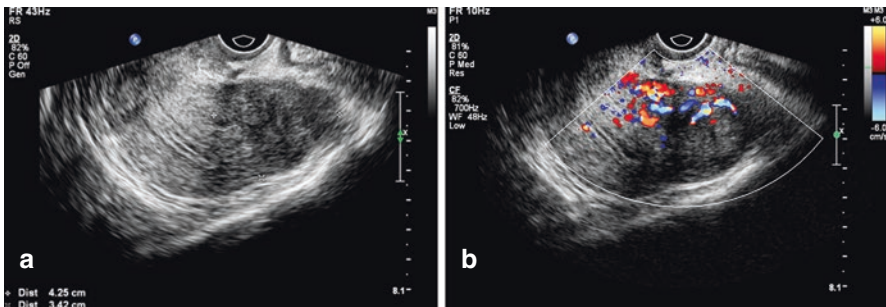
(a and b): TVUS images of focal adenomyosis in the posterior wall of the uterus, the uterus is retroverted. (a) is a grey-scale ultrasound image showing a hypoechoic area seen in the posterior wall of the uterus, protruding towards the surface of the uterus, with unclear boundaries, and the echo in the lesion is significantly uneven. (b) is a CDFI image showing a typical penetrating blood flow signal into the uterine lesion
